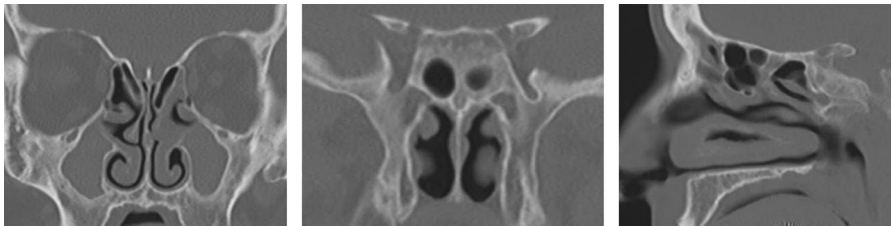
Computed tomography image of the paranasal sinuses in a patient with cystic fibrosis showing maxillary (*left*), sphenoid (*center*), and frontal (*right*) sinus hypoplasia. Also note the significant bony thickening and osteitic changes surrounding the borders of each sinus, suggesting chronic inflammation.
